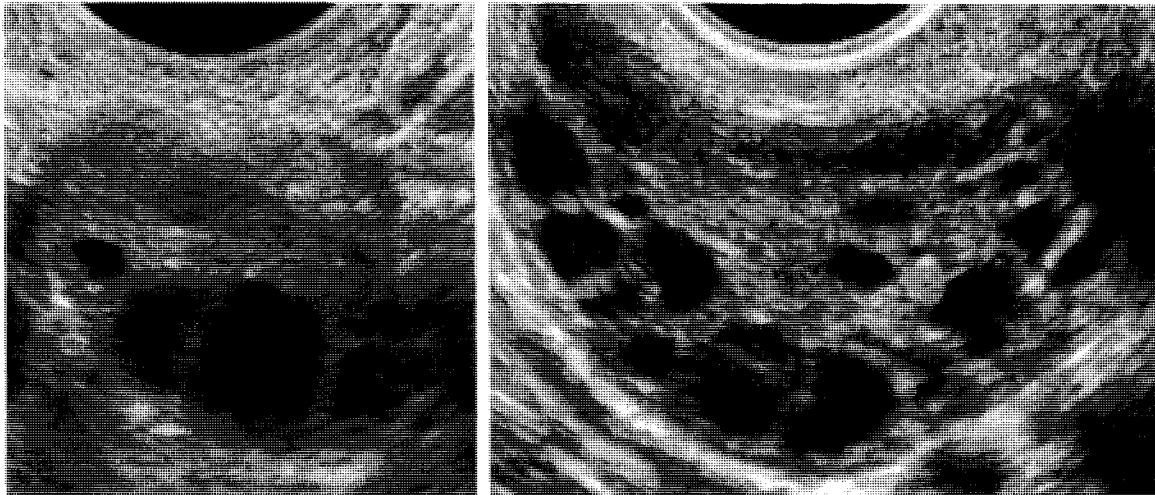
Normal (left) and polycystic ovary (right) shown by transvaginal ultrasonography during the follicular phase of a menstrual cycle. The fluid-filled antrum of a developing follicle appears as a dark circle. Compared with a normal ovary, the polycystic ovary is typically enlarged and contains an abnormally increased number of medium-sized follicles (Norman *et al* 2007).
